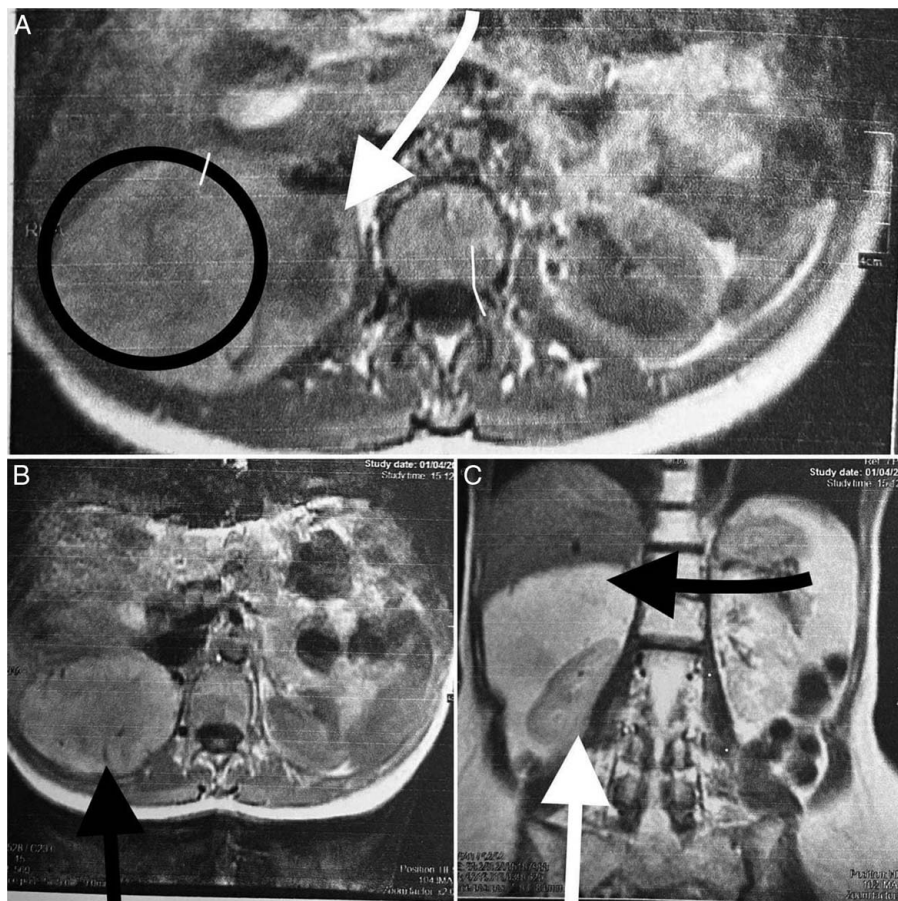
MRI images. (A) (T1 + C): axial MRI showing the large mass (black circle) attach into adjacent right kidney (white arrow) and push it inferiorly and medially. (B) (T1 + C): axial MRI showing the large mass (black arrow) at the upper pole of right kidney (located inferiorly to the mass, thus doesn't appear in the image). (C) (T2WI): sagittal MRI showing the mass (black arrow) surrounding the right kidney (white arrow).
